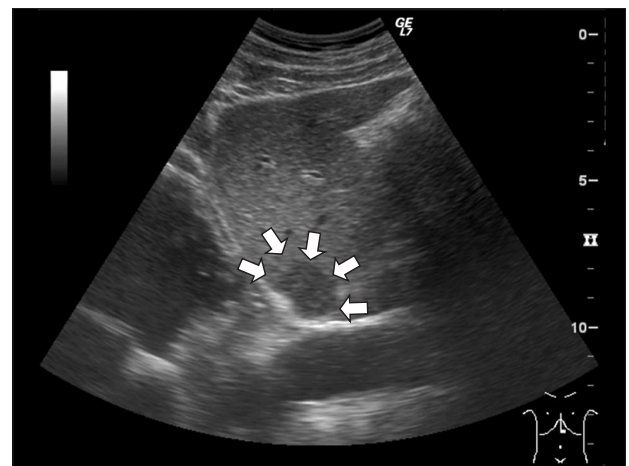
Ultrasound revealed a 2.5×1.7 cm sized nodular heterogenous hypoechoic lesion with clear margins in segment two of the liver.
